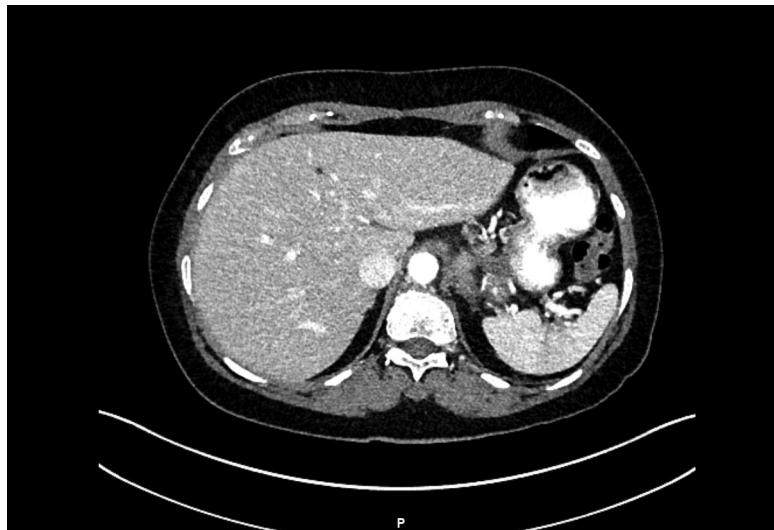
Computed tomography scan of the abdomen and pelvis with IV contrast, following diagnostic laparoscopy with abdominal washings, prior to definitive operation. Progression of infiltrative, ill-defined soft tissue located in the retroperitoneum, measuring 3.4×1.7 cm, and worsening left retroperitoneal adenopathy (yellow arrow).
